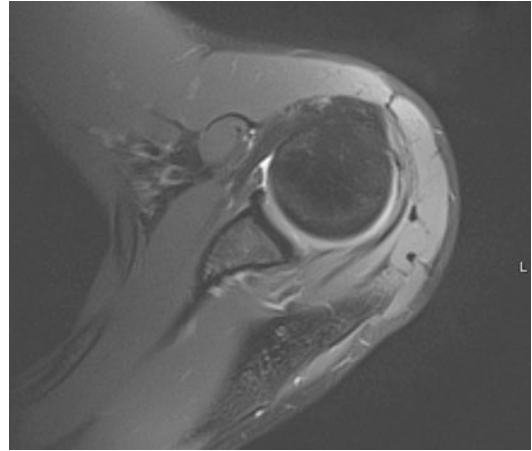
MRI of a shoulder with a Bankart lesion following a traumatic shoulder dislocation
